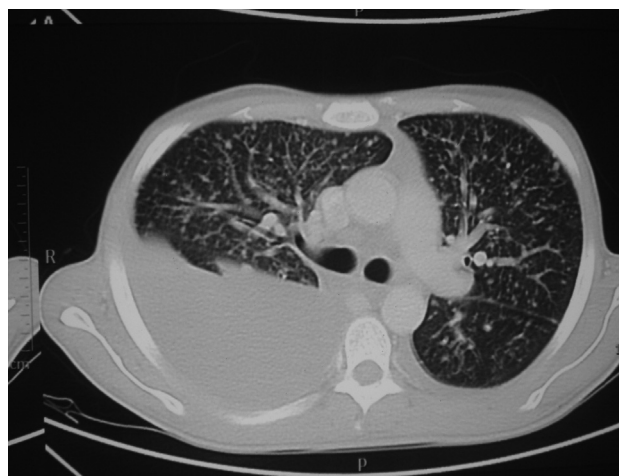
Massive pleural effusion in the right hemithorax, diffuse bilateral micronodular infiltration in both lungs, and hilar lymphadenopathy in thoracic CT.
